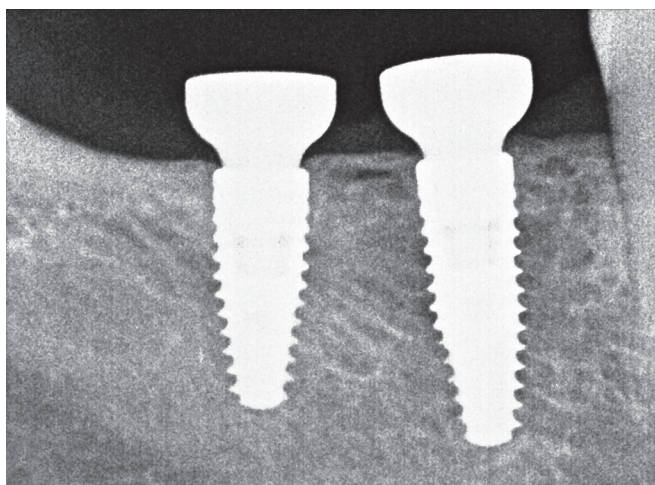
The intraoral periapical imaging-guided implant
